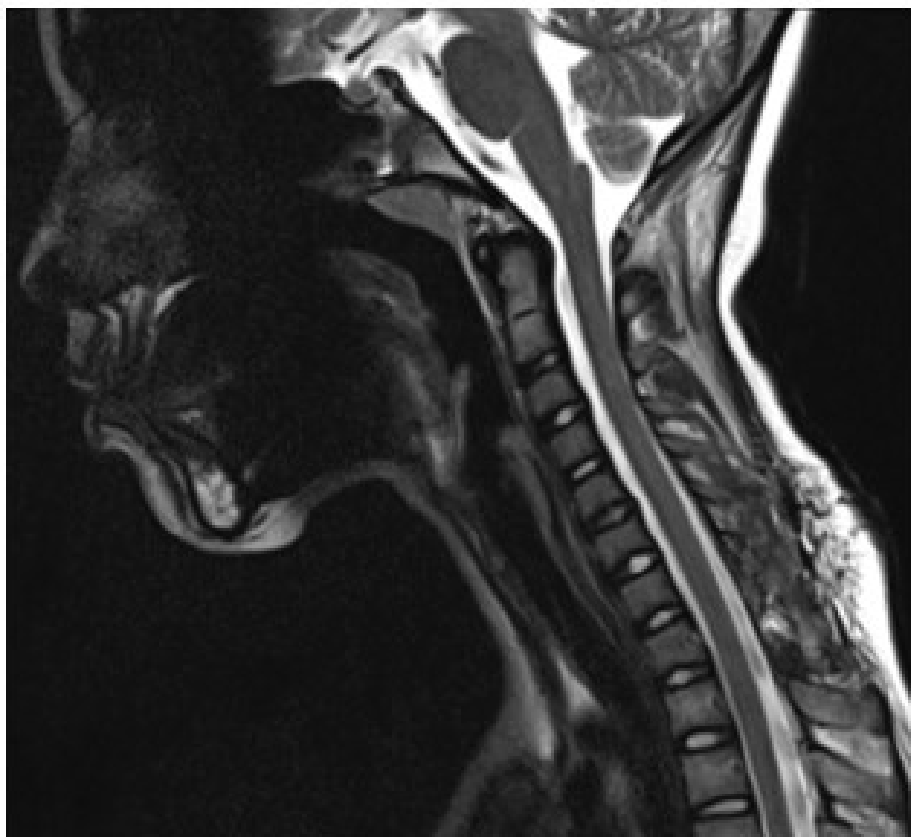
Case 2. Cervical hemorrhagic extradural cavernous hemangioma. Postoperative MRI. Sagittal section, T2WI showing no further bleedings and a realigned medullary cord. Partial restoration in cervical lordosis.
